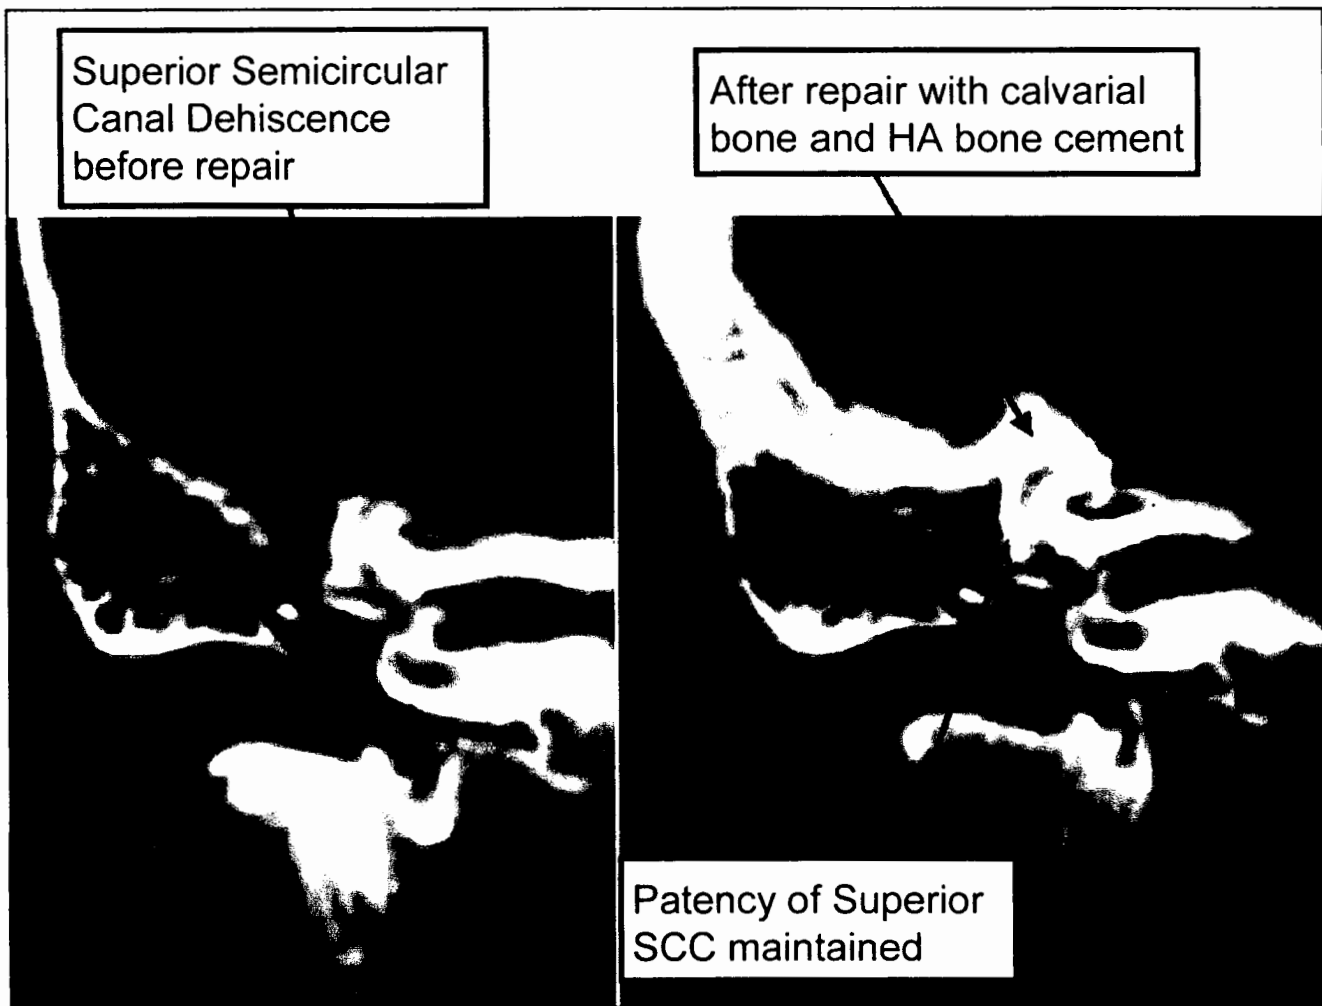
Preoperative (*left*) and postoperative (*right*) coronal CT scans in a patient who underwent middle fossa repair of SSCD with calvarial bone and HA bone cement. Note that patency of the superior canal is maintained and it is easily imaged postoperatively.
